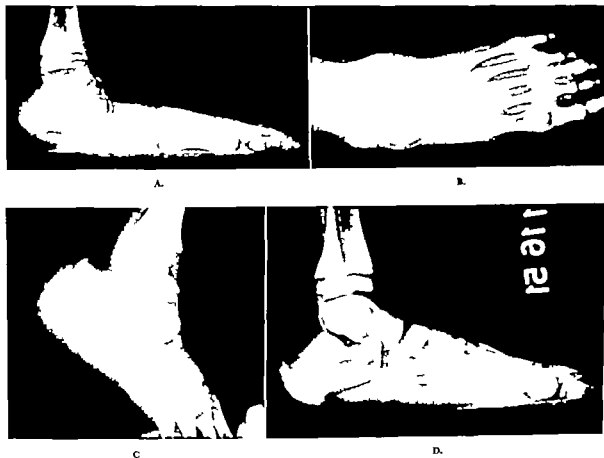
A, Lateral roentgenogram of the left foot, severe valgus, plantar flexed talus. B, Anteroposterior view left foot, lateral and posterior displacement of os calcis, abduction of forefoot. C, Lateral roentgenogram showing passive correction of deformity by placing foot in equinus and adduction. D, Lateral view of right foot for comparison. Slight posterior displacement of os calcis and obliteration of tarsal sinus, indicating mild valgus.
